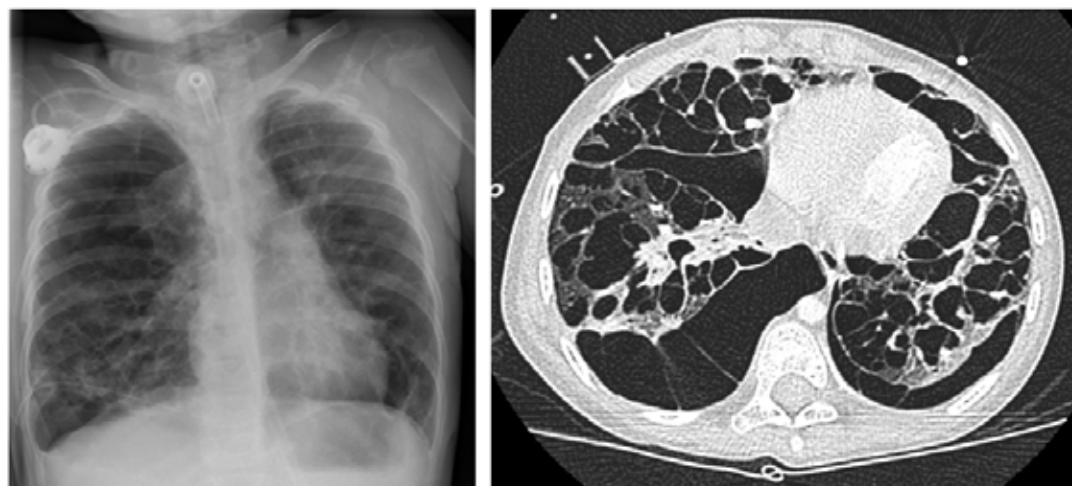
Chest X-ray and CT LCH of a nine-year-old boy with pulmonary Langerhans cell histiocytosis. The chest X-ray shows a mixture of air-filled cystic lesions, consolidation and hyperinflation. Notice the right-sided chest tube which was inserted. The high-resolution CT scan shows multiple bilateral cystic lesions of different size.
